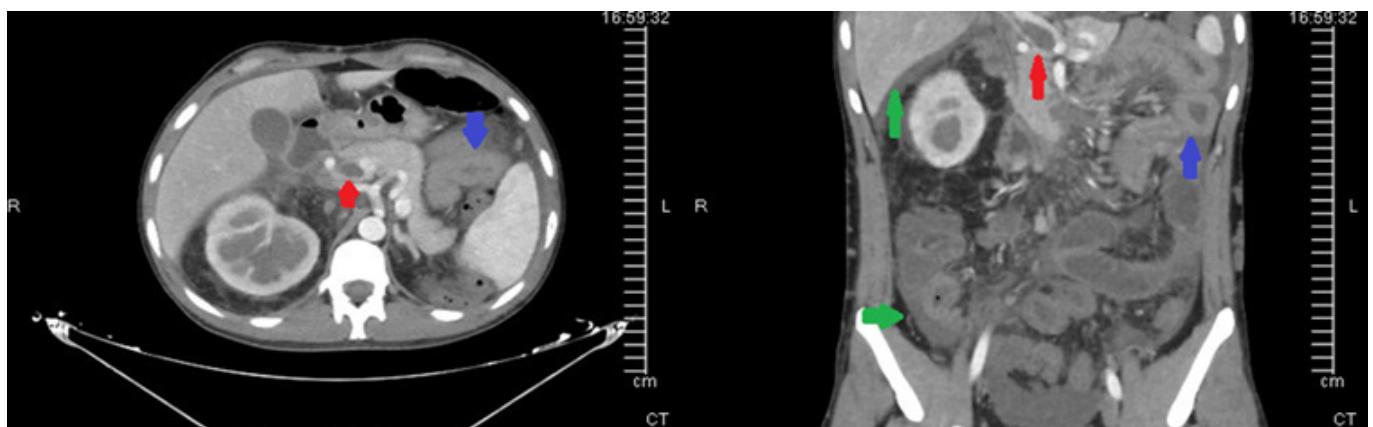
Portal venous phase CT shows thrombus in the SMV trunical segment (red arrow), edema and contrast uptake in the intestinal wall (blue arrow), minimal free fluid (green arrow)
